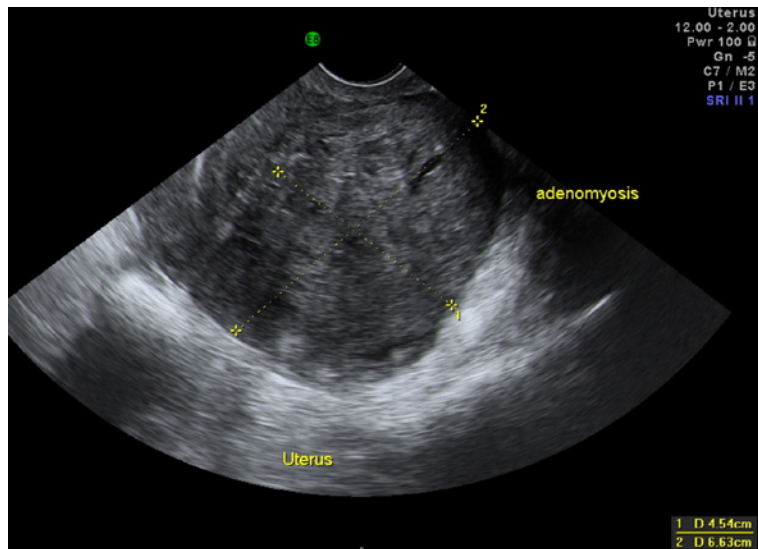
Ultrasound picture showing adenomyosis involving the posterior part of the uterus. Note: the edges are not well defined
